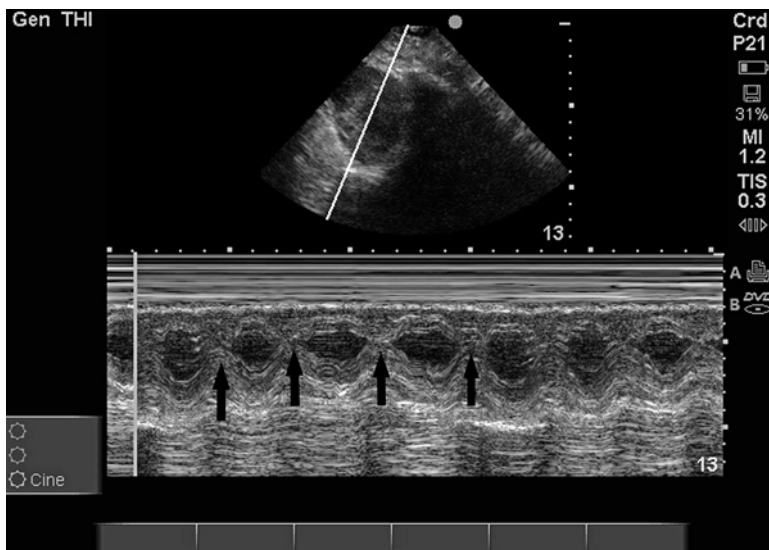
Echocardiography M-mode demonstrating hypovolemia. Patient with aSAH, cerebral salt wasting, and delayed cerebral ischemia. M-mode examination performed in the parasternal short axis view at the papillary muscle level. *Black vertical arrows* demonstrate end-systolic obliteration of the left ventricular cavity, suggesting significant hypovolemia and the need for fluid resuscitation
